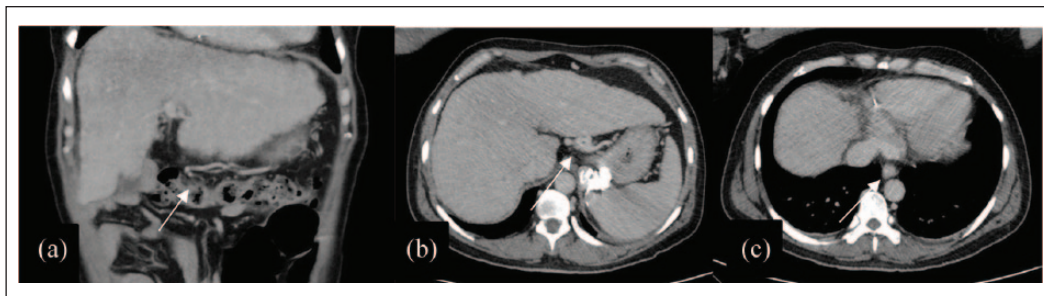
Preoperative contrast-enhanced abdominal CT scan from this patient shows portosystemic shunt. (a) Dilated gastroepiploic vein. (b) Dilated left gastric vein. (c) Esophageal varice.
